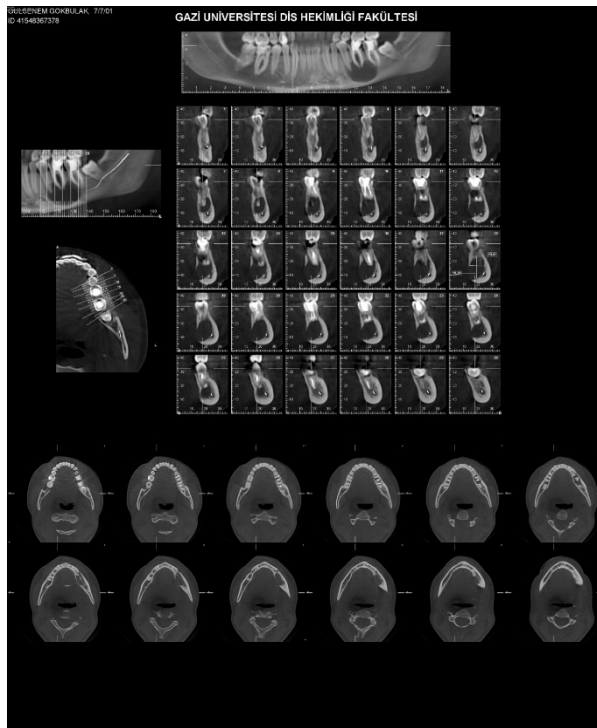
CBCT and Panoramic view of the lesion
